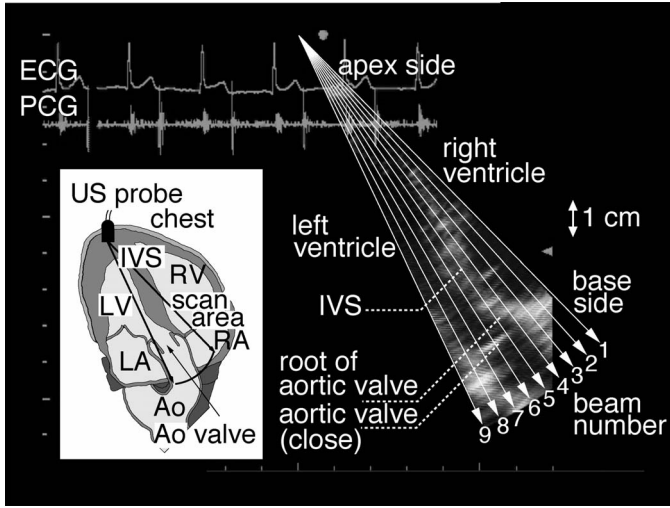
Cross-sectional image in the apical view exactly at the time of AVC ($t = T_0$) measured by a conventional ultrasonic diagnosis system for the same subject A as in Figs. 1, 2, and 3. Nine ultrasonic beams were used to measure the vibrations at points preset in the IVS for Fig. 5. The blue lines show the directions of the nine ultrasonic beams. The supplemental animation  shows the conventional B-mode image in the apical approach obtained by a conventional ultrasonic diagnosis equipment for subject A. This figure shows the cross-sectional image just at the time of AVC (T_0).
